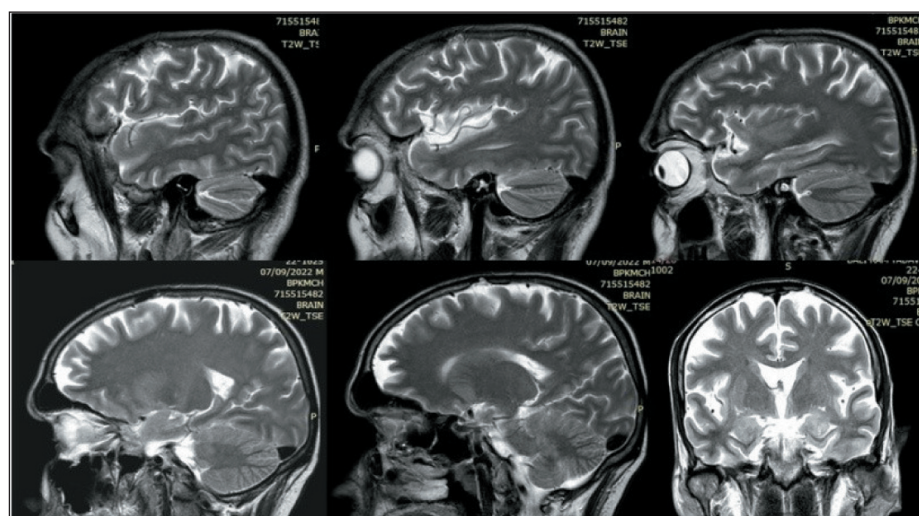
There is sclerotic changes like lesion on vertex of skull bone of MRI scan of brain. Note: created by the authors
